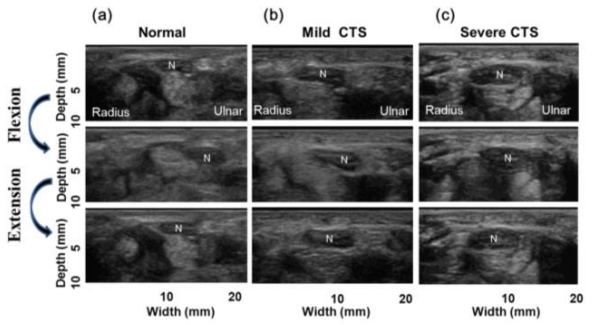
The ultrasound images of median nerves during fingers motion from different subjects: (a) a normal subject, (b) a mild CTS patient, and (c) a severe CTS patient. N indicates the median nerve.
